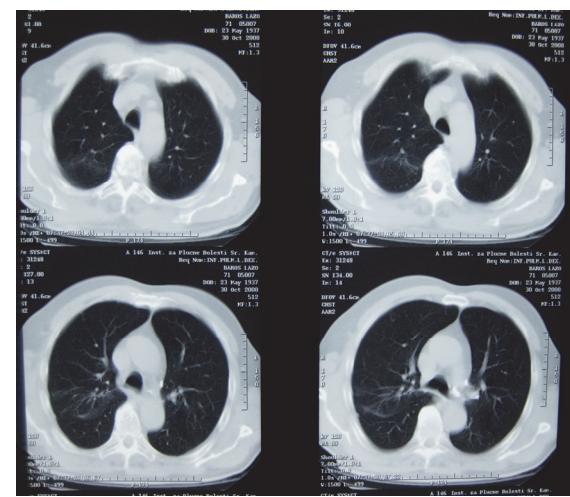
Control chest computed tomography finding: discrete zone of hypodense lesions in the right upper lobe
